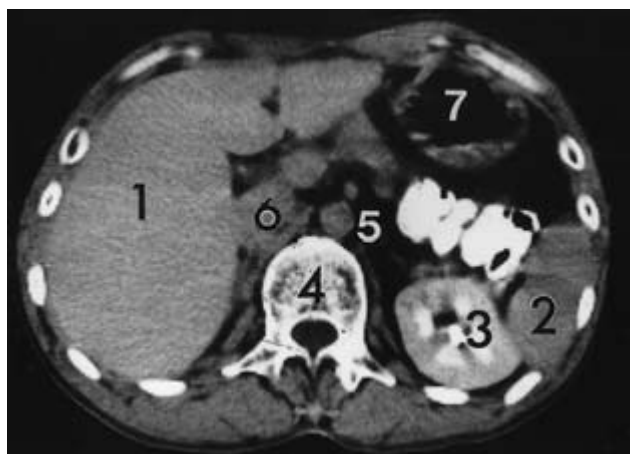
CT scan (enhanced by contrast) showing the liver (1), spleen (2), kidney (3), vertebral body (4), aorta (5), head of the pancreas (6) and stomach (7).
